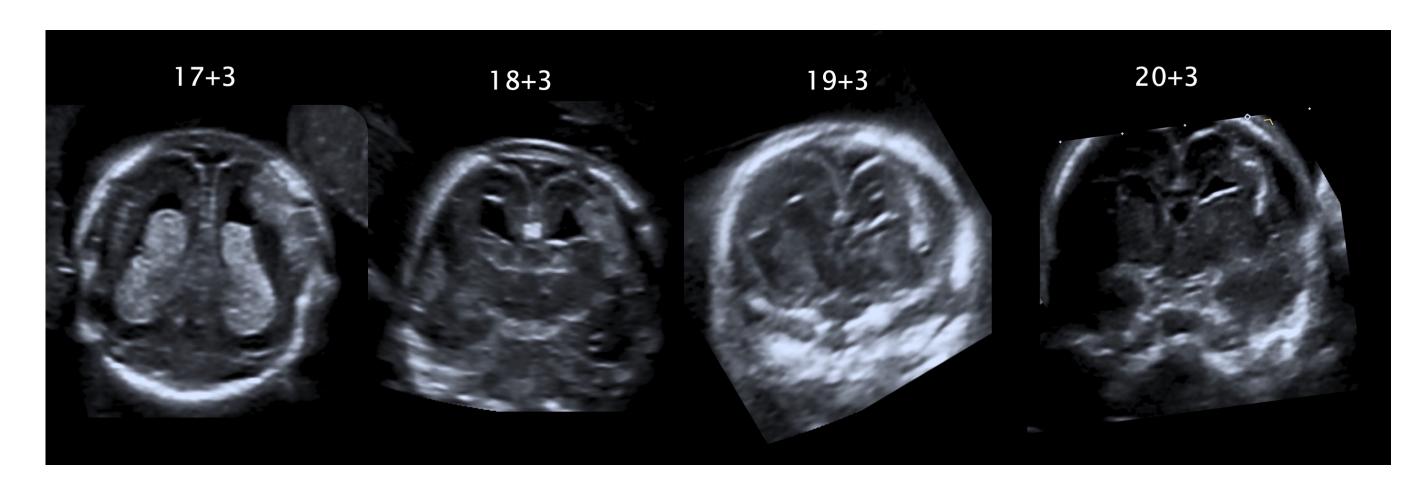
Sonographic presentation of the cortical defect from week 17+3 until 20+3.
